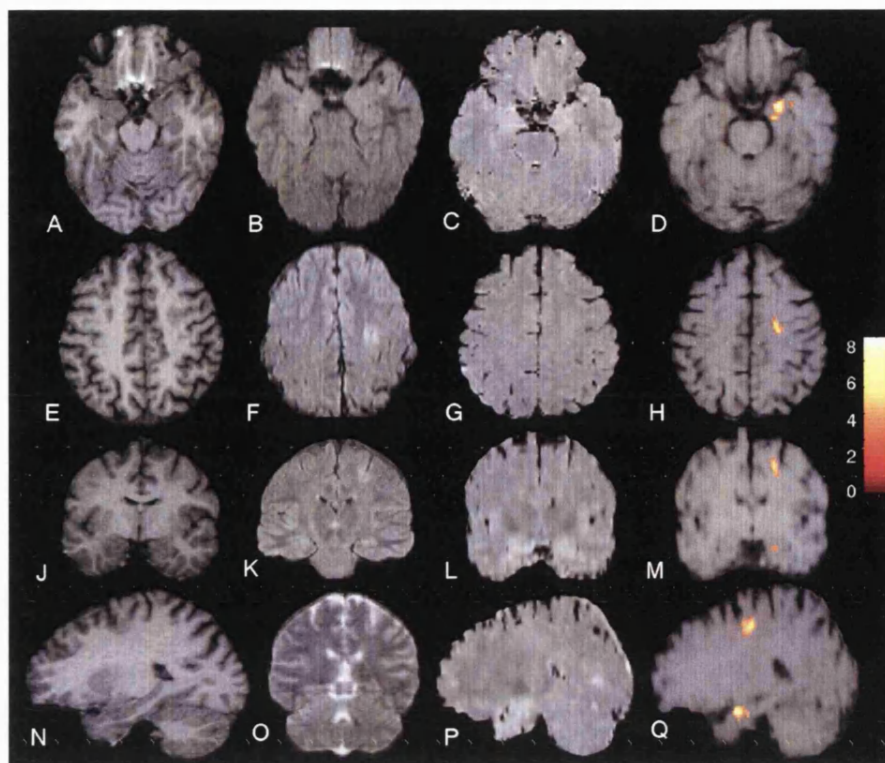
Patient 31. Right frontal (superior convexity) focal cortical dysplasia. (A, E, J and N) Inferior axial, superior axial, coronal, and sagittal T1-weighted images. (B, F, and K) Inferior axial, superior axial and coronal FLAIR images. (O) T2-weighted coronal image. (C, G, L and P) Inferior axial, superior axial, coronal, and sagittal T2 maps. (D, H, M and Q) Regions of significantly increased T2 superimposed on inferior axial, superior axial, coronal, and sagittal early-echo (proton-density weighted) images. These regions were used for quantitative region-of-interest analyses on the T2 maps (Table 5.4). The regions over the right superior frontal convexity coincide with the localization of the abnormalities identified on conventional MRI. The regions in the right mesial temporal lobe localized to normal appearing cerebral tissue. Z-value bar indicating degree of significance of highlighted regions is shown. Note that right on the images is patient's right.
